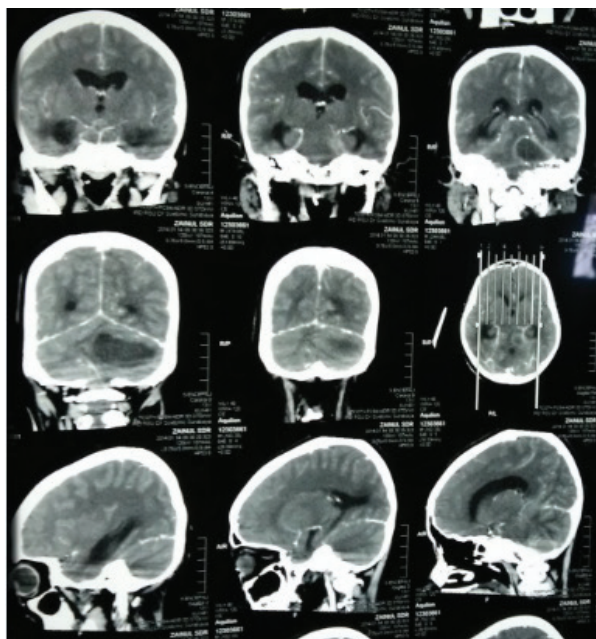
Head CT scan showed multiple contrast-enhanced hypodense lesions in left cerebellum and brain edema.
